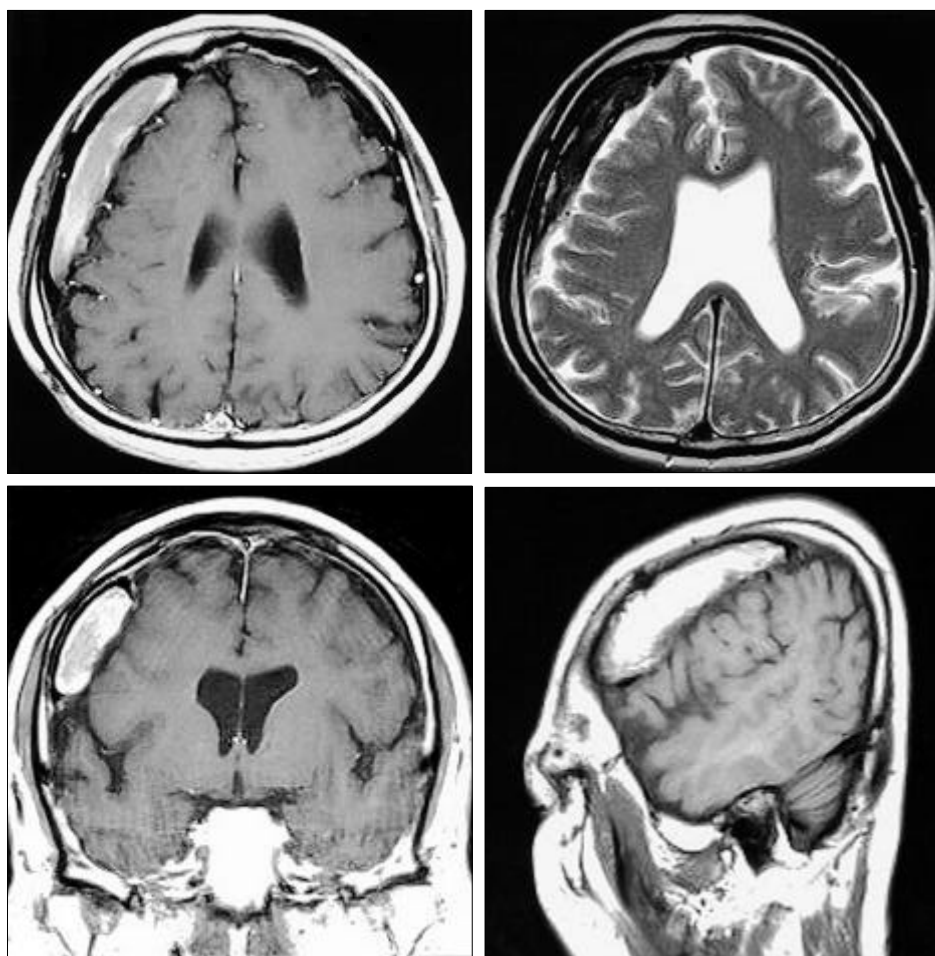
Preoperative axial T1-weighted, axial T2- weighted, coronal and sagittal MR images demonstrating an ossified subdural mass in the frontoparietal region. Note that this subdural mass is compressing the underlying brain.
